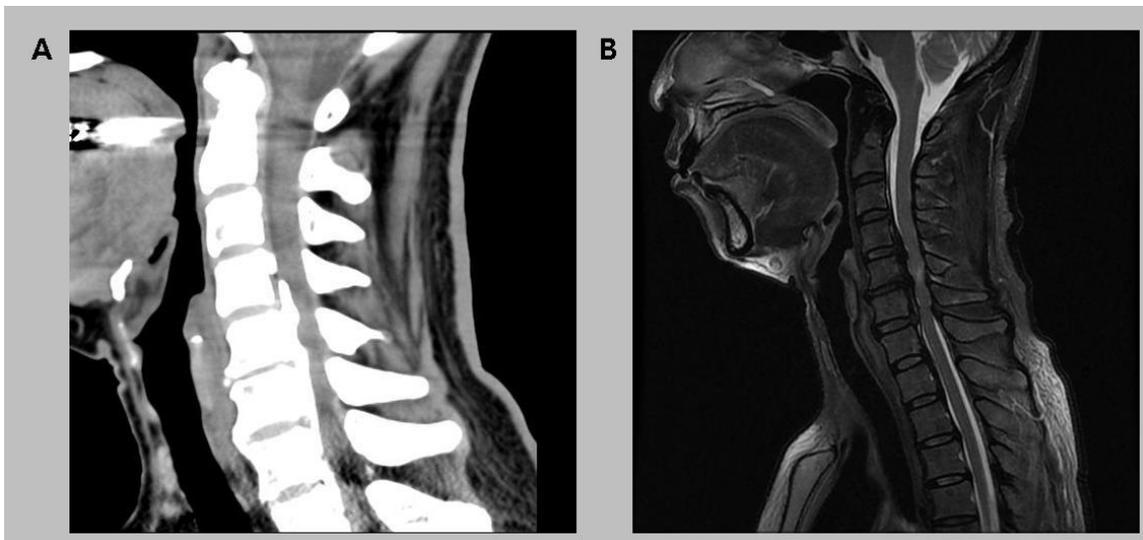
The sagittal CT (A) and T2-weighted cervical spine MRI (B) at 3 months after symptom onset showed ossification of the posterior longitudinal ligament at the level of C3-T1 with cervical cord compression and high signal intensity in the cervical spinal cord at the C5-6 disc space level.
